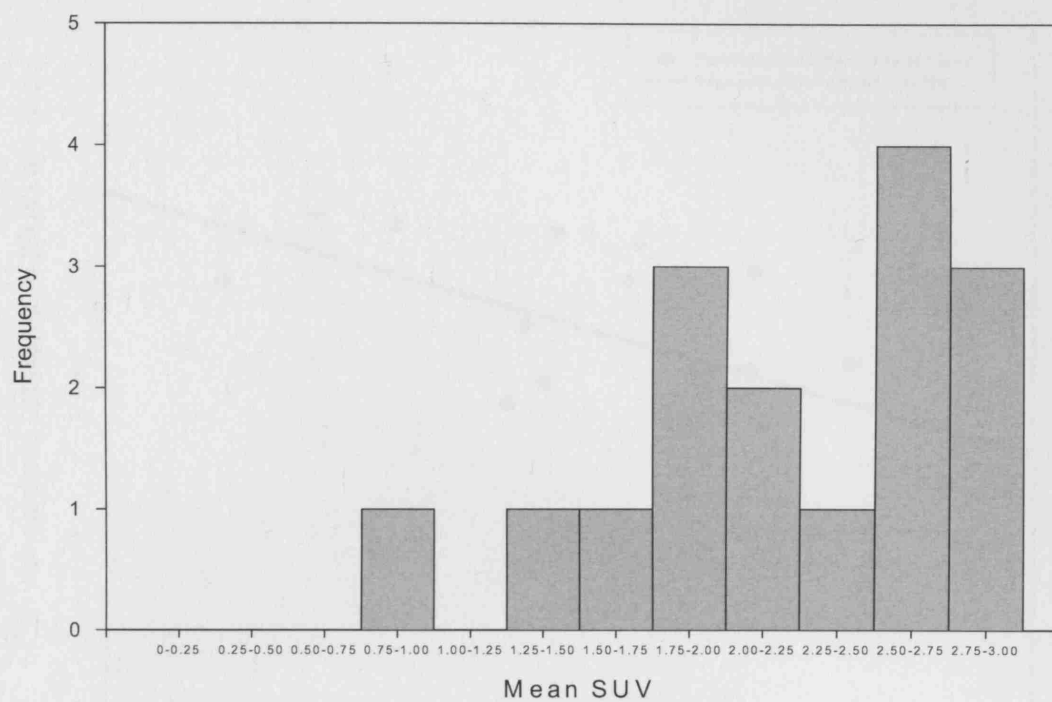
Histogram of individual mean tumour SUV summed from the 0-60 minute PET data acquisition (n=16)
